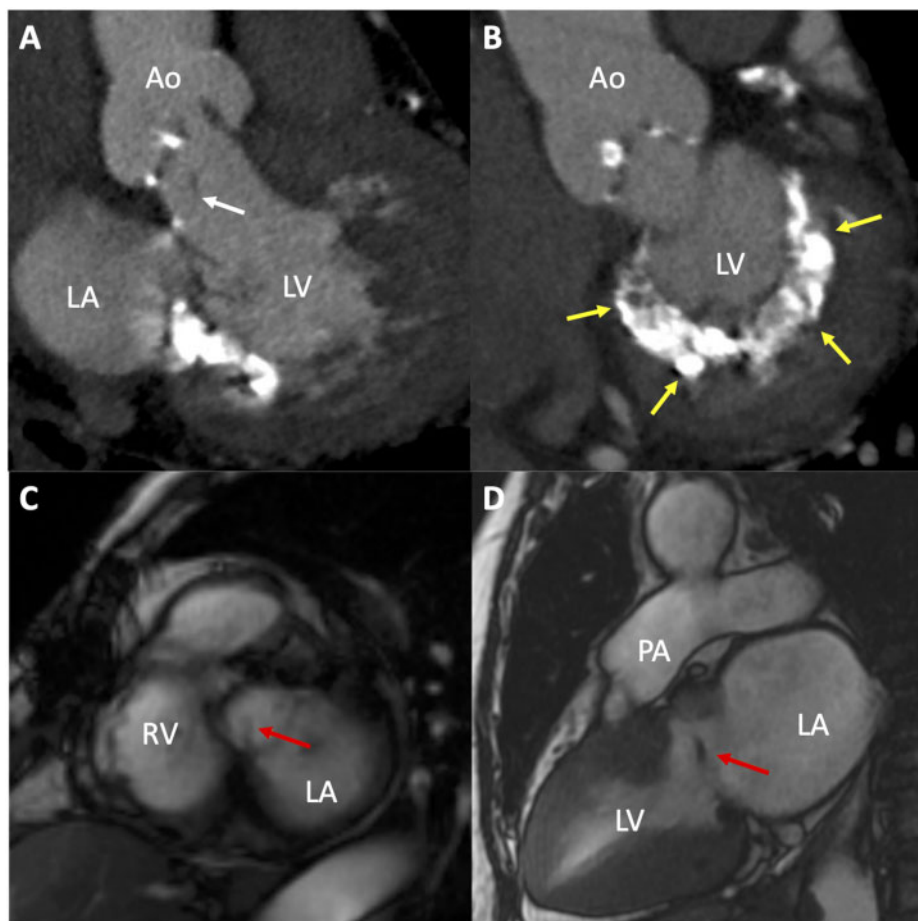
Imaging of the cardiac mass. (A and B) Contrast computed tomography (reformatted three-chamber view during the early contrast phase) showing a low-density string-shaped structure (white arrow) and mitral annular calcification (yellow arrow) in the posterior region of the mitral valve. (C and D) Cardiac cine magnetic resonance imaging showing a low-signal intensity structure (red arrows) between the non-coronary cusp of the aortic valve and the posterior commissure of the mitral valve. Ao, ascending aorta; LA, left atrium; LV, left ventricular; PA, pulmonary artery; RV, right ventricular.
